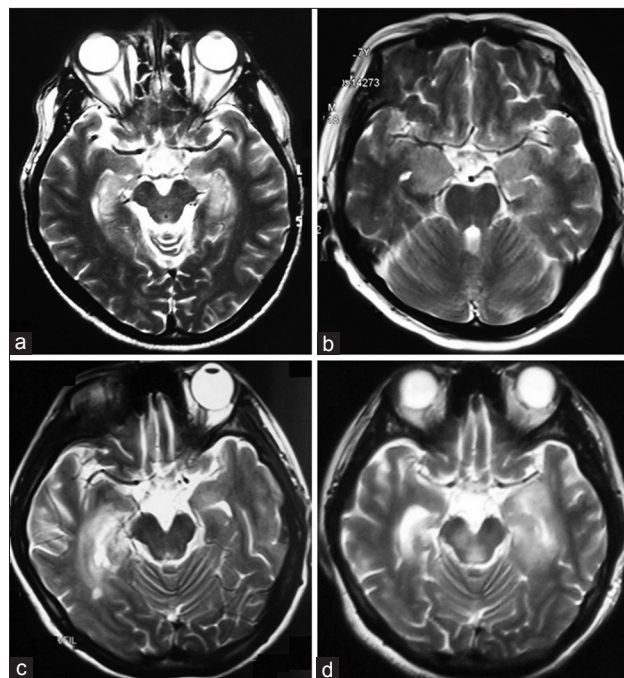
Brain MRI of autoimmune encephalitis. (a) High signals on bilateral mesial temporal lobe in a patient with limbic encephalitis associated with anti-GABA_BR antibodies. (b) High signals on the bilateral mesial temporal lobe and right amygdala enlargement in a patient with limbic encephalitis associated with anti-LGI1 antibodies. (c) Abnormalities in the right mesial temporal lobe in a patient with anti-NMDAR encephalitis during her initial episode. (d) New lesions more prominent at left mesial temporal lobe and brain stem during her relapse. MRI: Magnetic resonance imaging; GABA_BR: γ -aminobutyric acid B receptor; LGI1: Leucine-rich glioma-inactivated 1; NMDAR: N-methyl-D-aspartate receptor.
